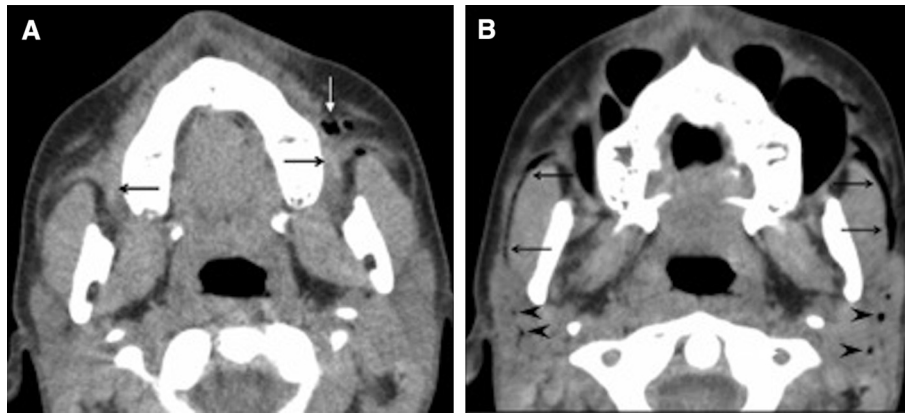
(A) Unenhanced computed tomography images of a 15-year-old girl evaluated for recurrent painless left cheek swelling and a suspected calculus in the Stensen duct. A calculus is not identified, but small, distal pericanalicular-located air bubbles (white arrow) are noted in the left buccal region, which suggests pneumoparotitis. Note the ampullar region and Stensen ducts (black arrows). (B) Images obtained with the patient performing a modified Valsalva maneuver resulted in air being visualized in both Stensen ducts (black arrows), in the parotid glands (arrowheads), and in the buccal soft tissues, which established the diagnosis of pneumoparotitis.
